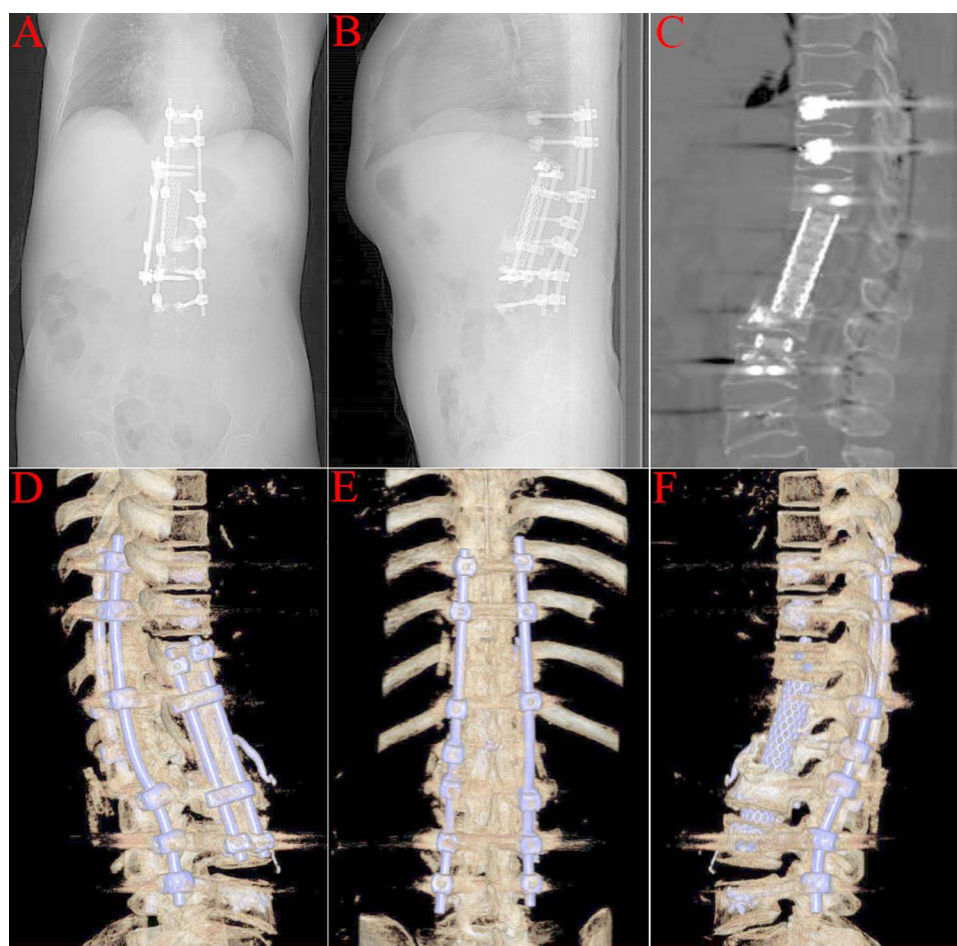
Computed tomography (CT) (thoracic vertebra). The position of the anterior titanium cage and posterior internal fixation was satisfactory. (A and B). DR, positive and lateral positioning images; (C). Sagittal reconstruction; (D–F). 3D reconstruction.
